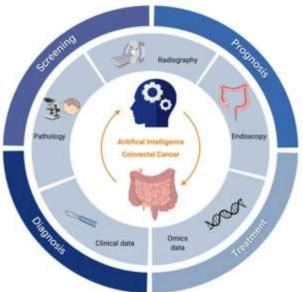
Clinical applications of AI in CRC. The inner circle depicts the primary data types in CRC research, such as radiological pictures (e.g. CT, MRI), endoscopic images, pathological images, clinical data, and omics data.
